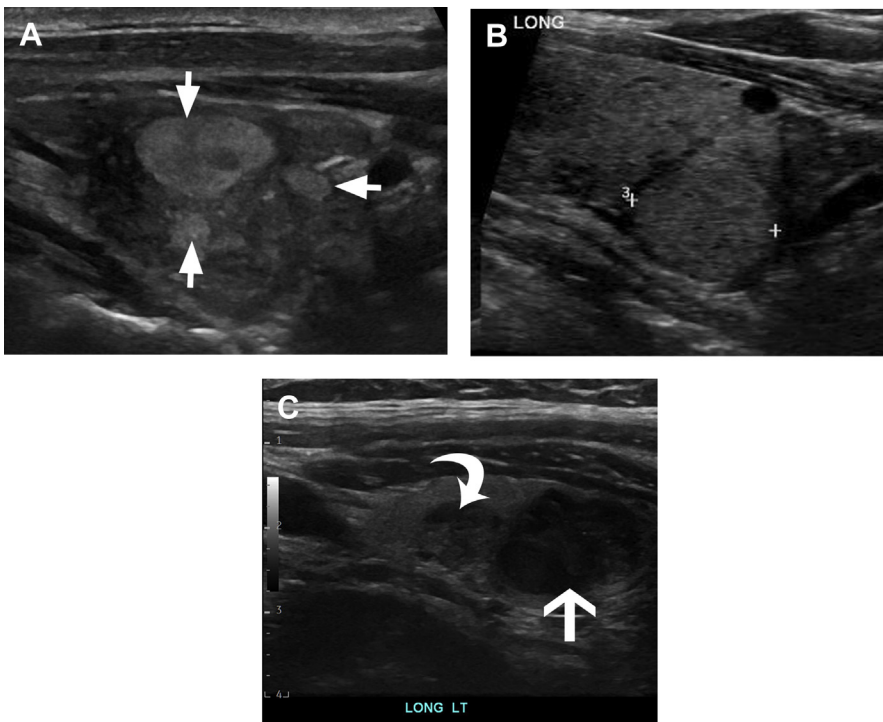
Nodule echogenicity on gray-scale ultrasound. (A) An 88-year-old man with hyperechoic nodules (*arrows*) and Hashimoto thyroiditis. (B) A 65-year-old woman with an isoechoic nodule (*calipers*). (C) A 51-year-old woman with nodules that are hypoechoic (*curved arrow*) and very hypoechoic (*arrow*).
